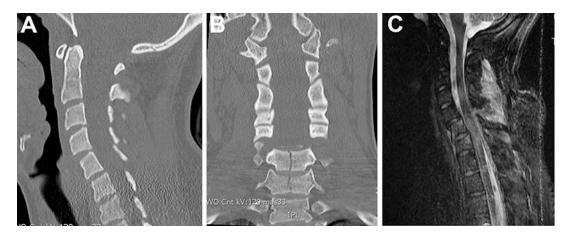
Sagittal (a) and coronal (b) CT demonstrating a coronally oriented fracture through C5 and C6. Sagittal stir sequence MRI (c) demonstrating significant C4-5 ligamentous injury as a result of a hyperflexion mechanism
